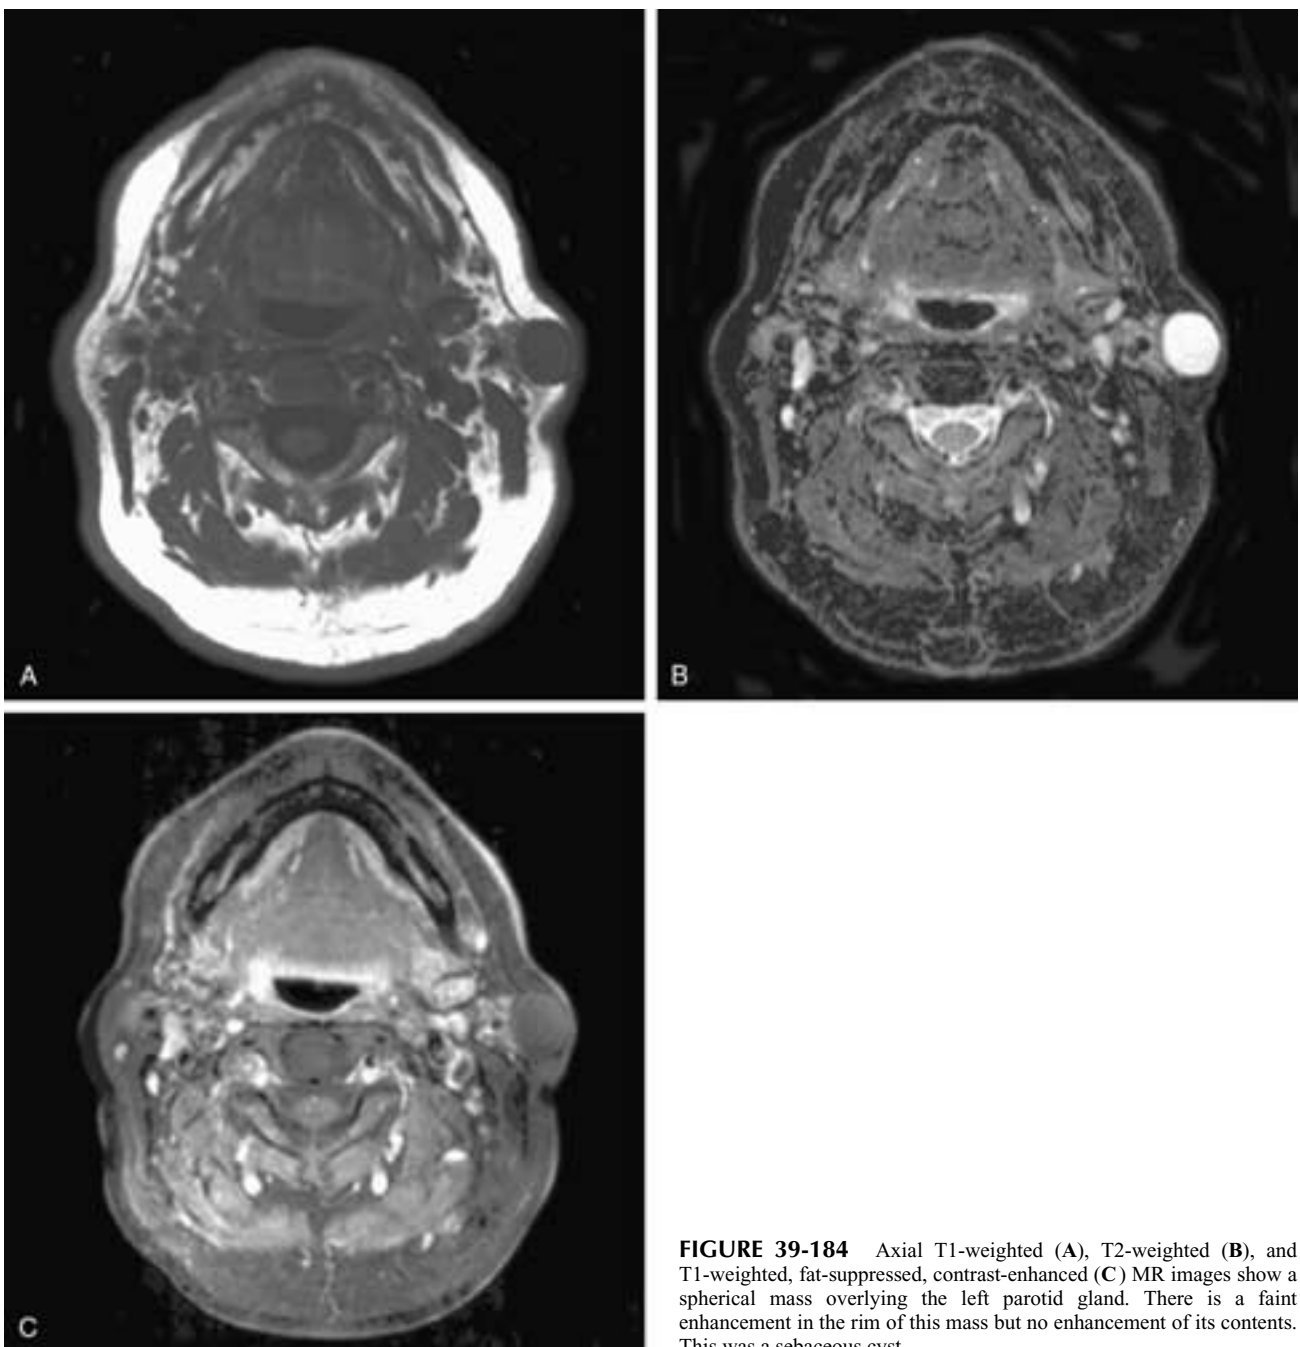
Axial T1-weighted (A), T2-weighted (B), and T1-weighted, fat-suppressed, contrast-enhanced (C) MR images show a spherical mass overlying the left parotid gland. There is a faint enhancement in the rim of this mass but no enhancement of its contents. This was a sebaceous cyst.
